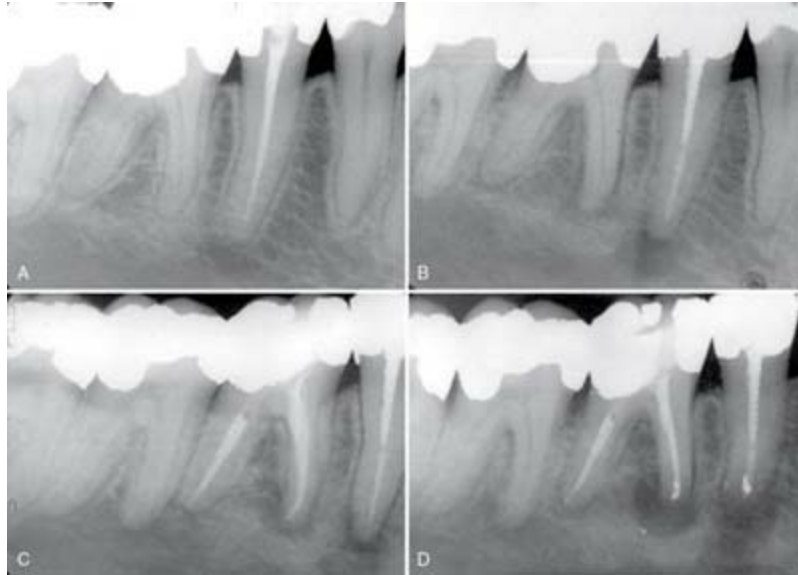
A, Periapical view of tooth #29 after endodontic treatment by a general dental clinician. The diagnosis was irreversible pulpitis. B, Patient was referred to an endodontist 4 months later to evaluate radiolucencies of teeth #29 and #30. Symptoms indicated irreversible pulpitis of tooth #30, with concurrent lower right lip and chin paresthesia. Past medical history revealed breast cancer in remission. C, Nonsurgical endodontics was performed on tooth #30. Immediate referral was made to an oncologist/oral surgeon for biopsy to rule out nonodontogenic origin of symptoms. D, Surgical posttreatment radiograph of teeth #29 and #30. The biopsy report confirmed metastatic breast cancer.
